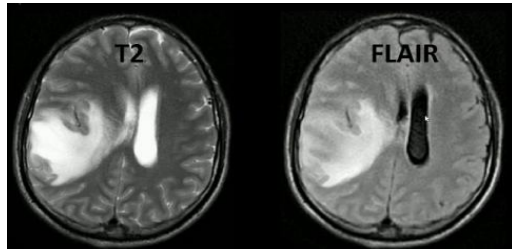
Brain Image showing the difference between T2 and FLAIR.
